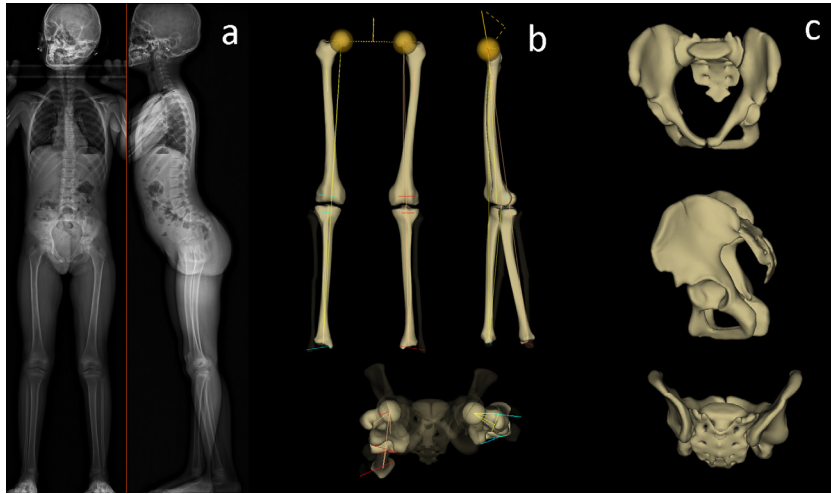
Example of (a) frontal and lateral EOS[®] radiography of a child with cerebral palsy (F, 8 years old) with 3D reconstructions of the lower limbs (b) and the pelvis (c) in coronal, lateral and transverse views.
